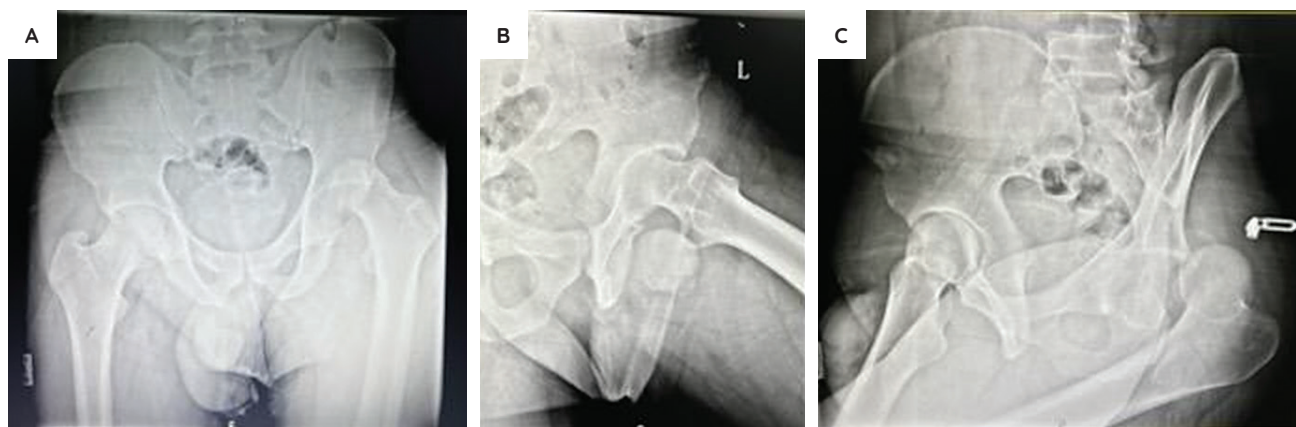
Pre-operative radiographs—anteroposterior (AP) pelvis (A), lateral hip (B), and Judet oblique view (C)—obtained on the day of consultation in the Emergency Room, 6 weeks post-injury.
